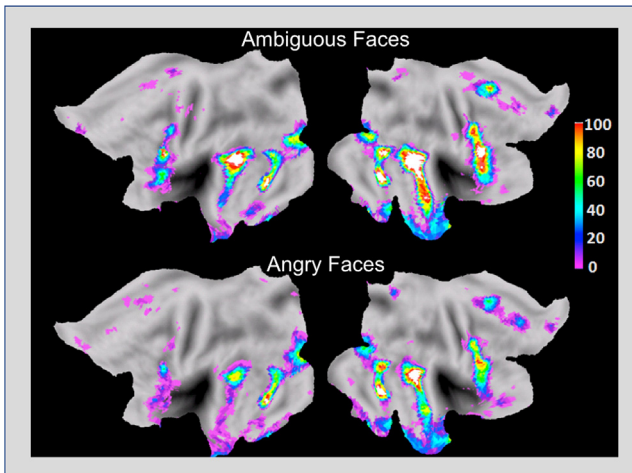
Probability maps of the ambiguous (a) and angry (b) contrasts between the face and control stimuli displayed of the flattened cerebral cortex. Left and right hemispheres are displayed on the left and right, respectively. Reprinted from Tahmasebi, A. M., Artiges, E., Banaschewski, T., Barker, G. J., Bruhl, R., Büchel, C., Conrod, P. J., Flor, H., Garavan, H., Gallinat, J., Heinz, A., Ittermann, B., Loth, E., Mareckova, K., Martinot, J. L., Poline, J. B., Rietschel, M., Smolka, M. N., Ströhle, A., ... Paus, T. (2012). Creating probabilistic maps of the face network in the adolescent brain: A multicentre functional MRI study. *Human Brain Mapping*, 33(4), 938–957. <https://doi.org/10.1002/hbm.21261>. Reprinted with permission.
